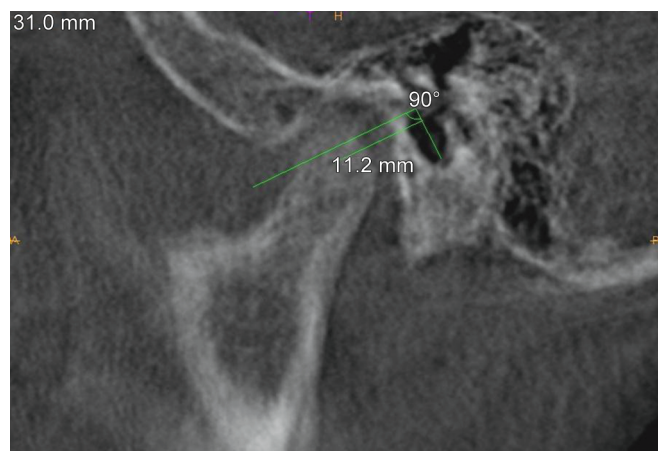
Cone-beam computed tomography (CBCT) scan of condylar position pretreatment
